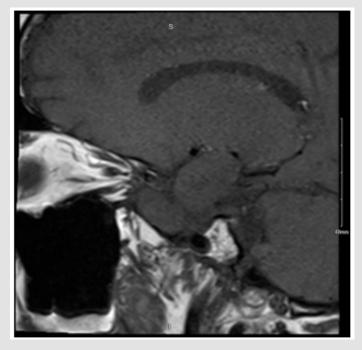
MRI of the patient's Brain. Impression: Normal appearance of the sella and pituitary. Please note that dynamic postcontrast sequences were not performed, such that a microadenoma is not excluded.
